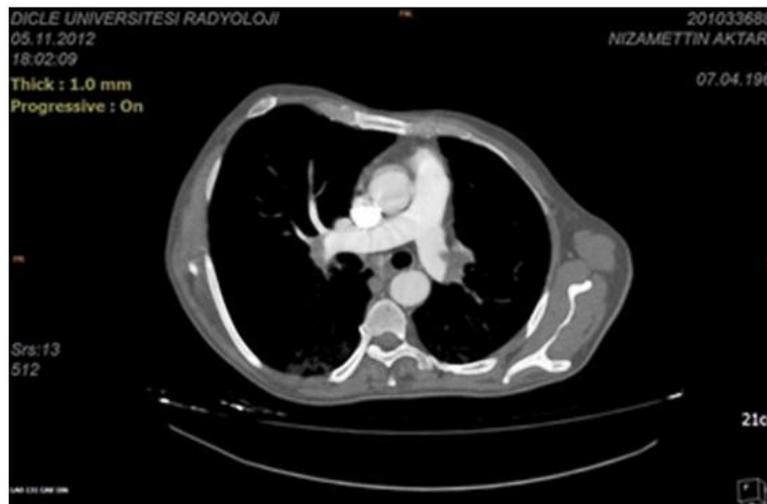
Thorax CT of the case with increased liver size and hypodense lesion.
